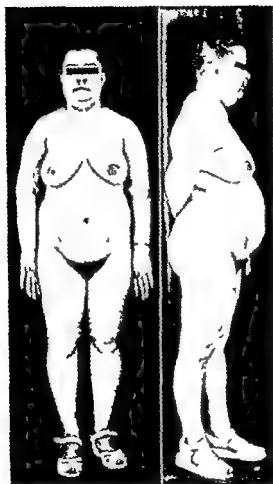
CUSHING'S SYNDROME (See Protocol 11 XXIV) Re-establishment of menstruation and loss of weight without dieting after roentgen therapy
